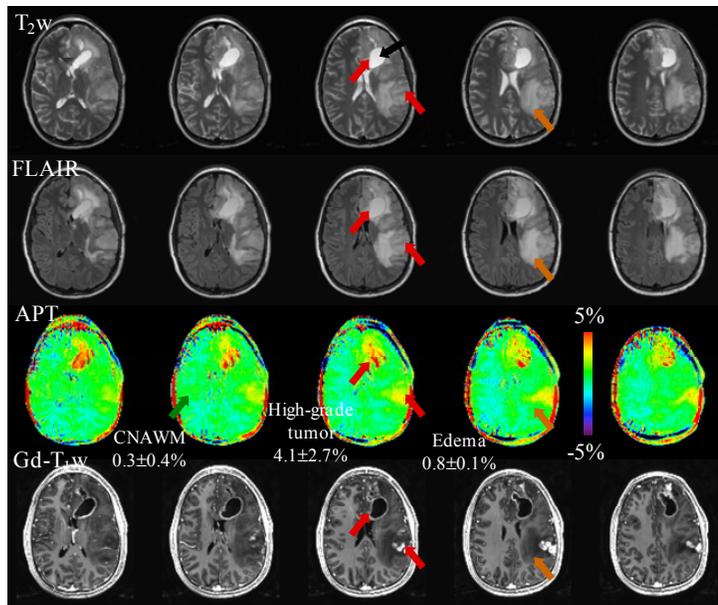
APT and conventional MR images for a patient with a multi-focal grade-3 AA. Red arrow: tumor core; black: cystic cavity; orange arrow: peritumoral edema; green arrow: CNAWM. APT imaging shows that the tumor cores (red arrow) are hyperintense.
